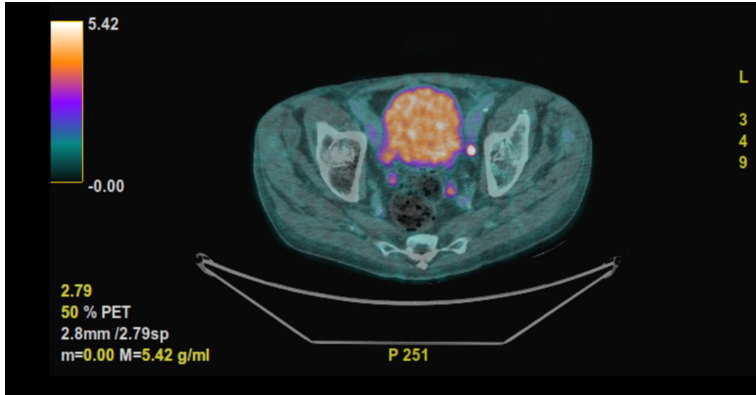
CT-PET imaging shows avid uptake in the internal iliac lymph nodes demonstrating metastatic disease.
